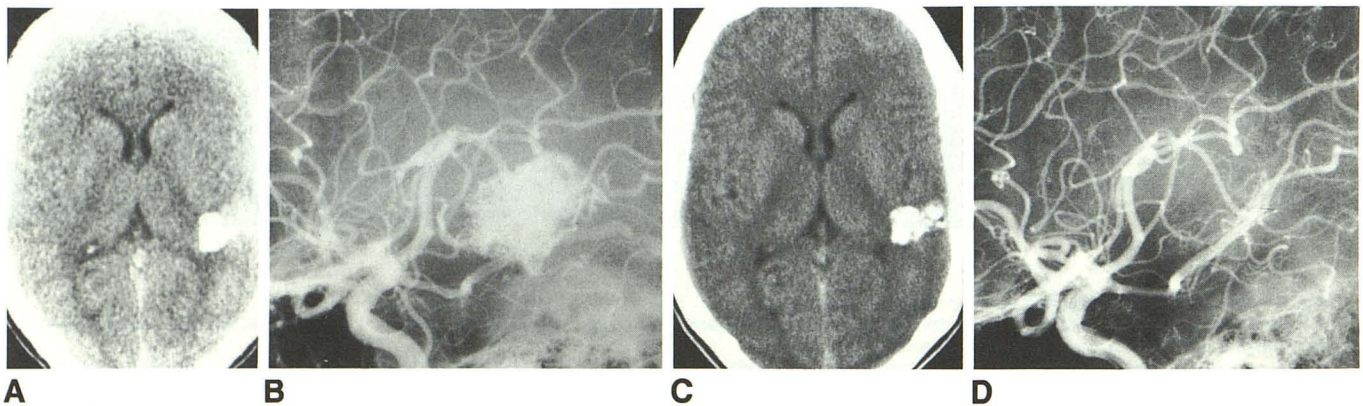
A–D, Radiologic evaluation in May 1984 (A and B) and August 1986 (C and D) of a man with an arteriovenous malformation (AVM). A, Unenhanced CT scan shows calcific, enhancing posterior temporal lesion, which showed minimal enhancement after injection of contrast medium. B, Lateral projection of left carotid angiogram shows AVM irrigated by posterior temporal branch of middle cerebral artery and draining into vein of Labbé. C, Unenhanced CT scan shows that left posterior temporal lesion is densely calcified. No enhancement was seen after injection of contrast medium. D, Lateral projection of left carotid angiogram shows resolution of AVM.
